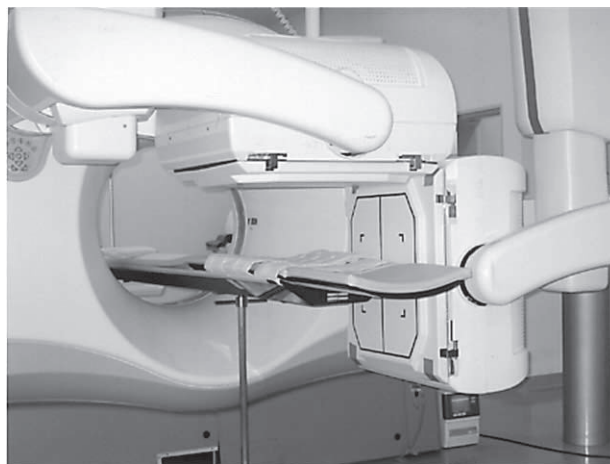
Photograph of our combined SPECT/CT system with its adjacent SPECT and CT scanners without need for repositioning of the patient. The patient table from CT scanner extends into the gantry-free SPECT system.
